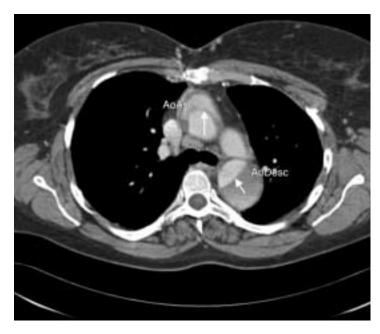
CT image of type A dissection. Transverse slice at the level of main pulmonary artery. Clearly visualized dissection flap (see arrows) in ascending aorta (AoAsc) and descending aorta (AoDesc). Thrombus in false lumen.
